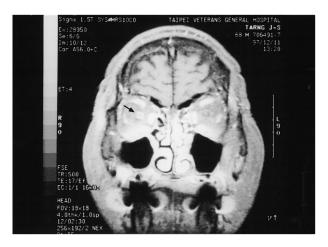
Case 2: Magnetic resonance imaging revealed ring-shaped enhancement over right optic nerve (arrow), extending from just behind eyeball to orbital apex (T_1 -weighted coronary scan, contrast enhancement).
